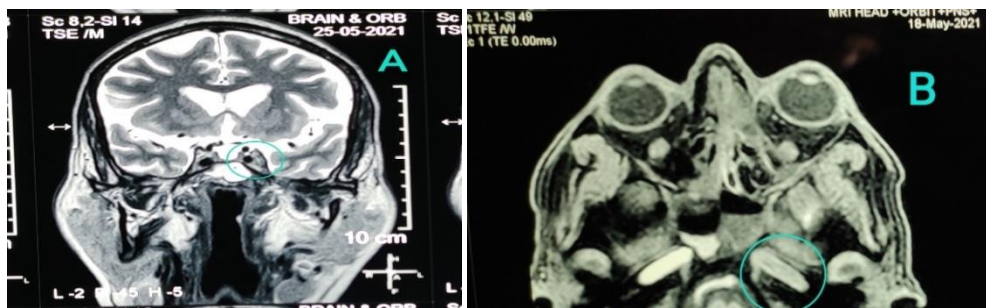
contrast enhanced T2W MRI showing left cavernous sinus thrombosis
